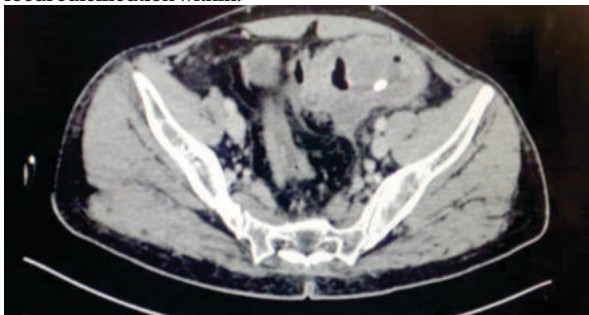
CT axial image shows asymmetrical heterogenous enhancing exophytic circumferential trans-mural wall thickening seen in sigmoid descending colon with large extra-luminal enhancing soft tissue associated with focal calcification within.
